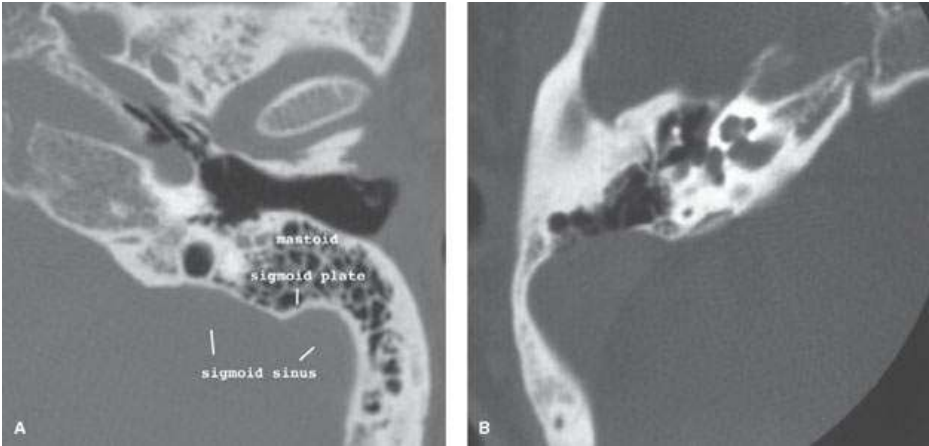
A: Computed tomography showing the close relationship between the mastoid and the sigmoid sinus. B: Rarely, dehiscence of the sigmoid plate can be seen as an anatomic variant.
